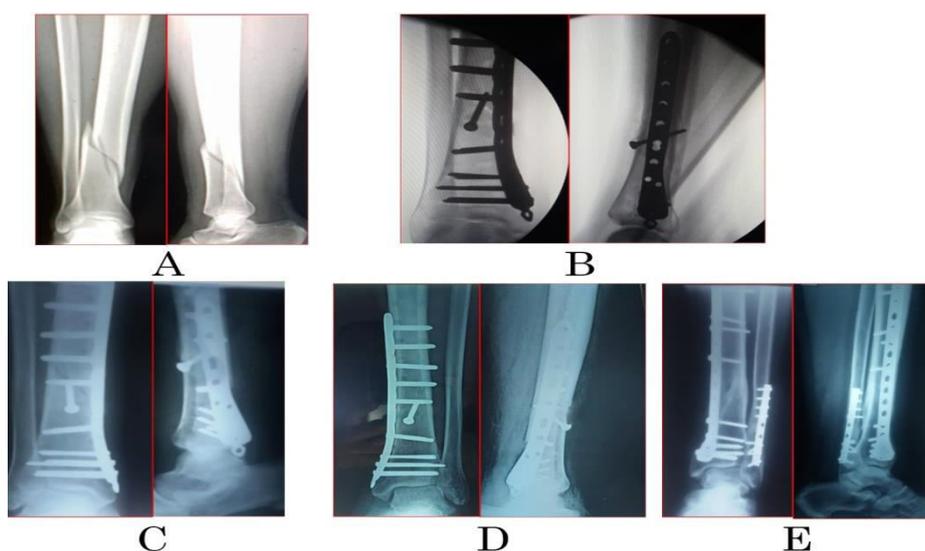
A case of male patient (30 years) old, no comorbidities, RTA, closed right fracture of lower third tibia 43A1 was fixed by MIPO, without fracture of fibula. A: pre operative x-ray AP and lateral. B: Post operative x-ray AP and lateral. C: follow up after 2 months AP and lateral. D: follow up after 4 months AP and lateral, the patient had deep infection, we did debridement and he taken I.V. A.B. according to C&S. E: After 6 months AP and lateral, the patient had osteomyelitis, we did removal
